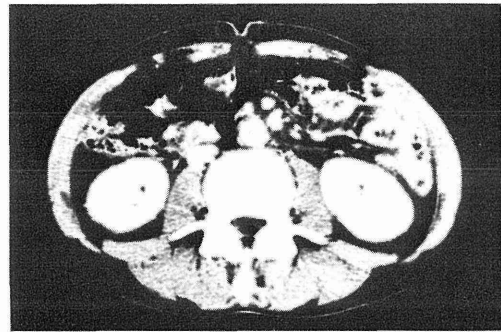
Abdominal CT after cytoreductive surgery.
